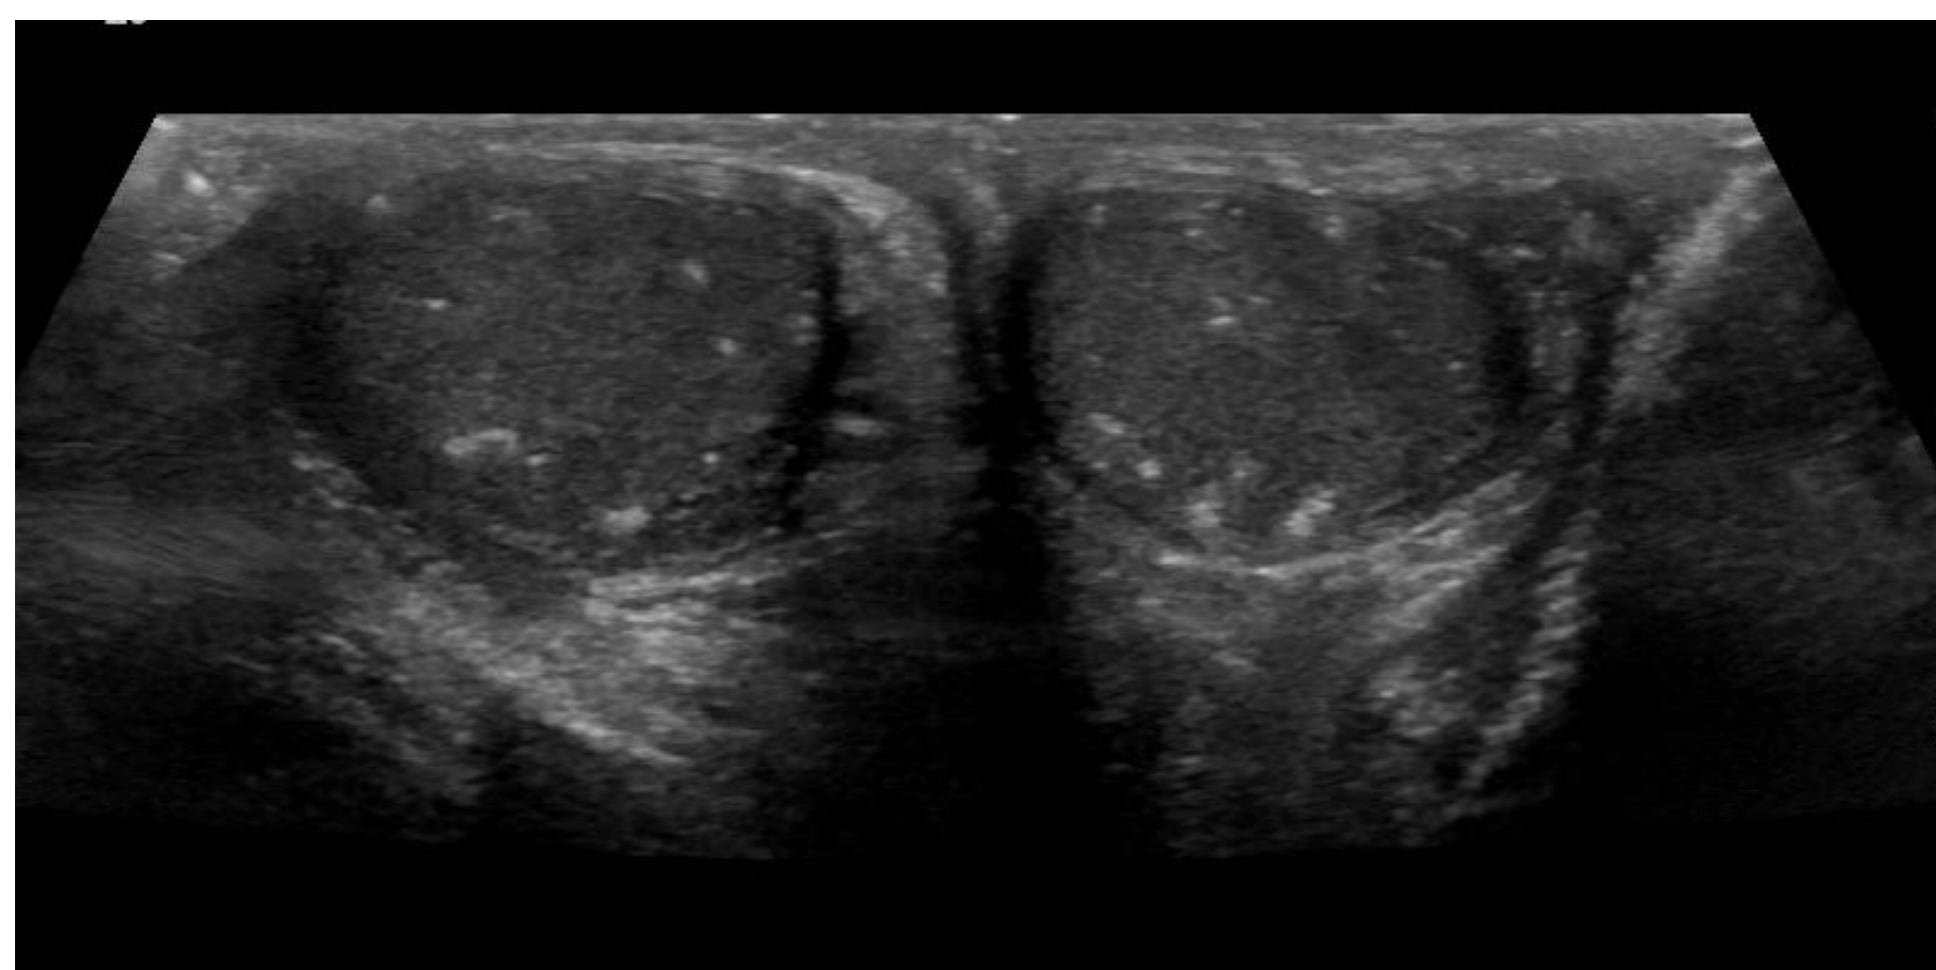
Testicular Ultrasound. Transverse view of both testes; showing multiple irregular echogenic foci throughout the testes bilaterally consistent with coarsened calcified lesions, most consistent with multiple large cell calcifying Sertoli cell tumours.
